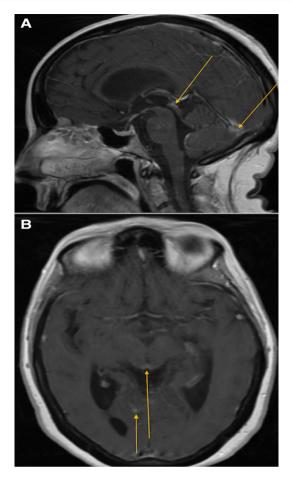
Images (A) and (B) show tectal plate and occipital enhancement on sagittal and axial T1 postcontrast MRI of the brain, respectively (October 2020).
